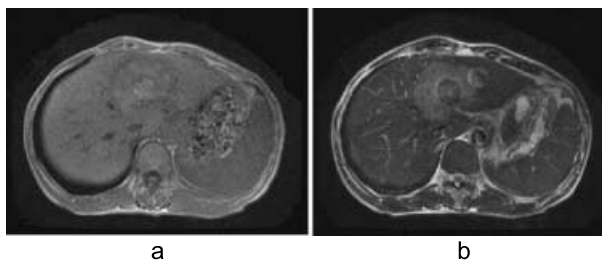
MRI (a) : T1 weight image (b) : T2 weight image MRI shows that iso-high intensity lesion with low intensity ring and high intensity central area on T1 weight image. T2 weight MRI shows high intensity lesion with slight high intensity area in center.
